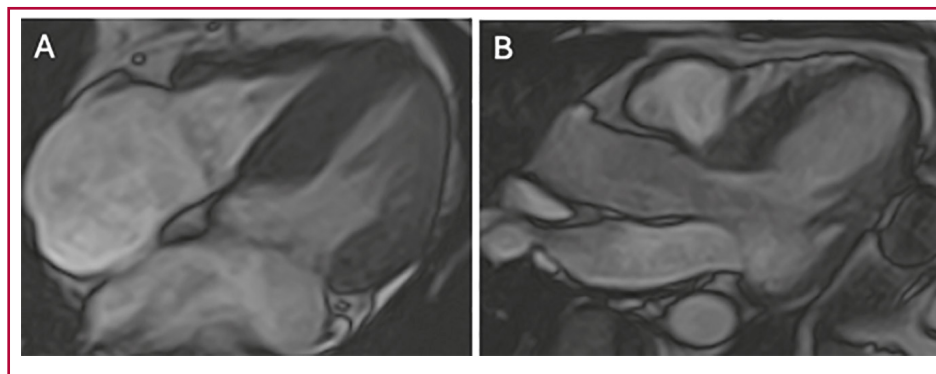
Cardiac magnetic resonance imaging. A) Four chamber view with significant thickening of the interventricular septum. B) Left ventricular outflow tract, with absence of obstruction.
